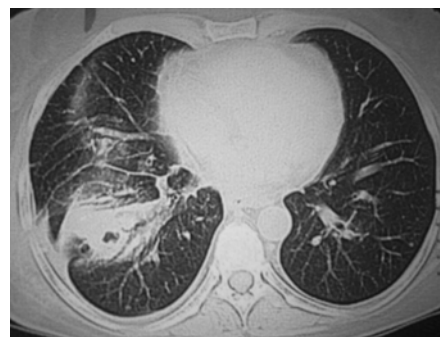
Chest CT-scan after initiation of anti-TB medication
